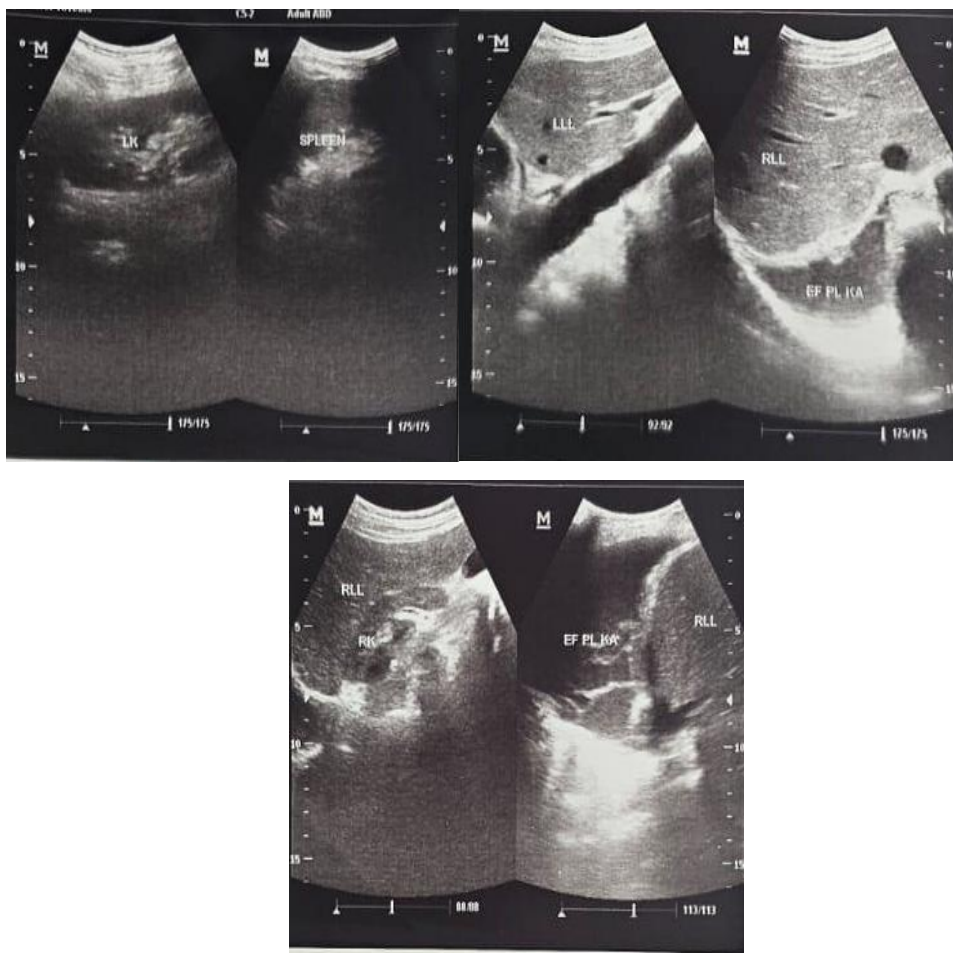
Abdominal ultrasound with impressions of abdominal organs within normal limits.
